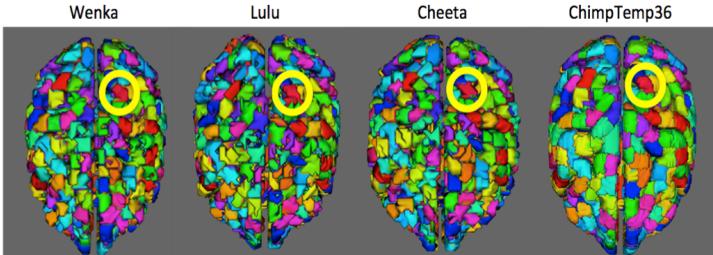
Parcellation schemes in the diffusion space of each chimpanzee subject and the original one derived on the chimpanzee T1-weighted template.
